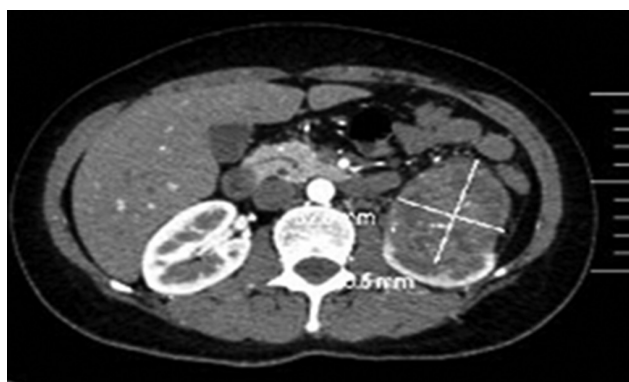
Enhanced computed tomography (CT) scan showing uneven enhancement of some tissues, with an average CT value of 75 Hu.
